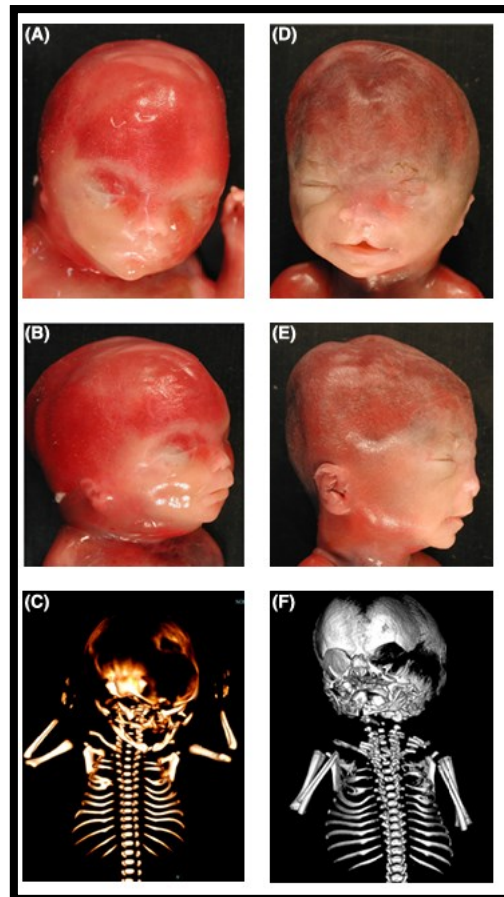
The CT scan reveals the facial appearance of 1st fetus in C, A, and B, as well as the facial appearance of the 2nd fetus in F, E, and D. There are noticeable anomalies in the ribs on both sides in (C) and (F). Adapted from (Rinaldi et al., 2022).
